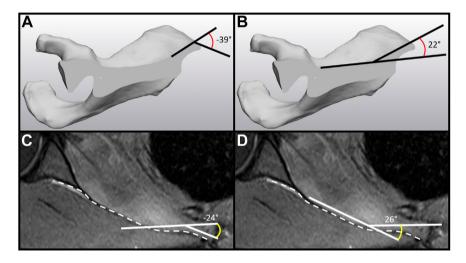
In this type 3 concave scapula taken from a segmented CT, measuring the angle of the medial protuberance gives a scapula with a negative MSCA (A). Measuring from the tip of the protuberance gives a positive MSCA (B). On a typical volumetric image, both measurements are viable. In this MRI of a type 3 concave scapula, the curvature of the scapula is shown in a *dashed line*, while the angle is shown in *yellow*. Measuring the angle from the medial edge of the protuberance gives a negative MSCA (C). Measuring from the prominent edge of the protuberance gives a positive MSCA (C). *CT*, computed tomography; *MRI*, magnetic resonance imaging; *MSCA*, medial scapula corpus angle. Panes C and D were adapted from Spiegl et al,²⁰ with permission from Elsevier.
